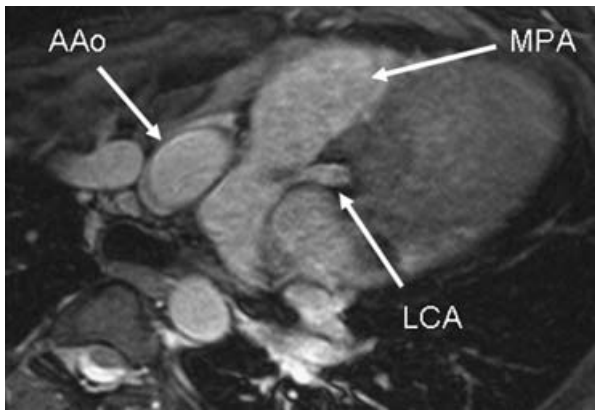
This magnetic resonance image demonstrates anomalous left coronary artery (LCA) from the pulmonary artery (MPA). Note the mild loss of signal in the MPA where the LCA inserts, signifying turbulent flow from the LCA into the MPA.
